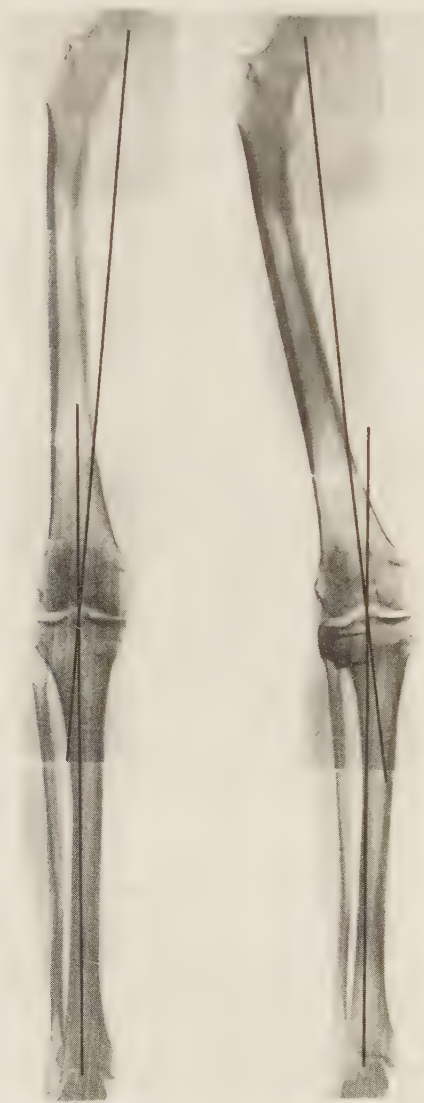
Whole lower limb radiograph in standing position in a man 52 years old with medial arthrosis Stage I in his right knee (left). The varus deviation of the mechanical axis is 5° . One year after the osteotomy the deviation of the mechanical axis is 8° valgus and the medial joint space has now opened up in the standing position (right).
